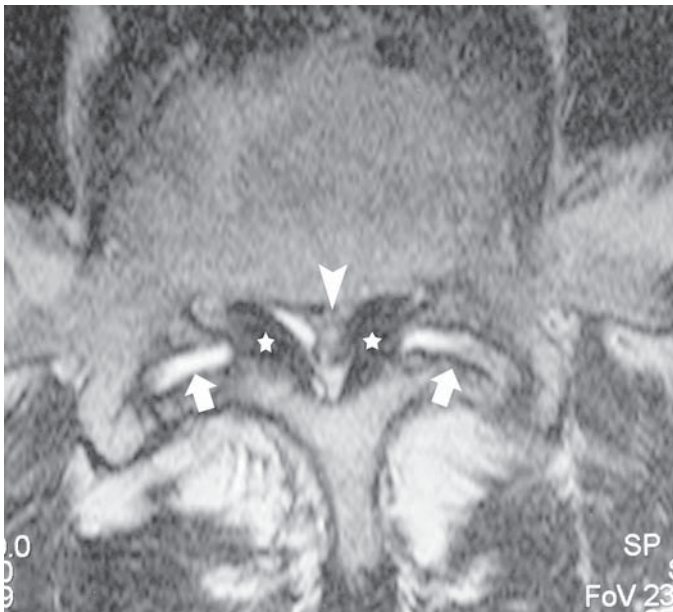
Central canal and lateral recess narrowing. Axial T2-weighted image shows significant narrowing of the central canal (*arrowhead*) and lateral recesses which is in part due to ligamentum flavum hypertrophy (*stars*) and in part due to facet hypertrophy with additional fluid present in the facets (*arrows*).
